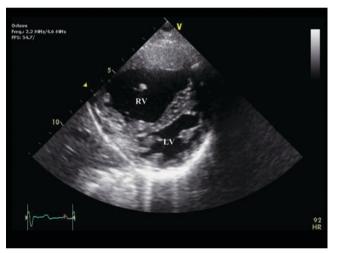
Echocardiography documenting severe PAH with right-toleft shift of the interventricular septum in a short-axis view (LV left ventricle, RV right ventricle)
